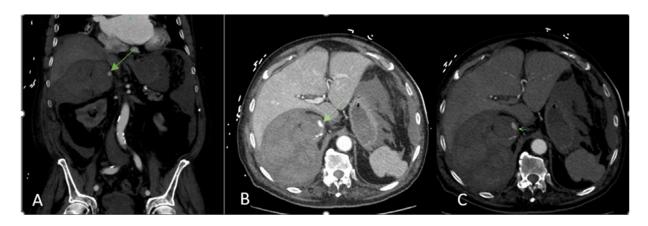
Abdominal and pelvic CT of the 86-year-old gentleman on representation (Case 1) showing. (A) CT Angiogram of the Abdomen, identifying focal hyperattenuation in the right adrenal hematoma consistent with active bleeding. (Green arrow) The mean density of ovoid mass is 52.7 HU with medial hyperdense lesion; the mean density is 180 HU. (B) Contrast-enhanced CT of the Abdomen in the late arterial phase. Hyperdense focus is consistent with active bleeding. (Green arrow) The mean density of ovoid mass is 52 HU and medial hyperdensity is 205 HU. (C) CT Angiogram of Abdomen with arterial phase, Hyperattenuating focus consistent with active bleed. (Green arrow) The mean density of ovoid mass is 51.3 HU and medial hyperdensity 162 HU.
